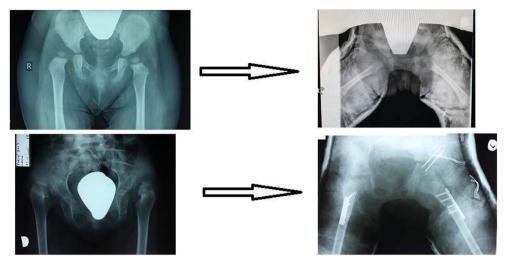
Patient's X-rays—upper row representing preoperative state and state after bloody reposition, lower row shows pre-operative state and after operative treatment using an anterior approach
